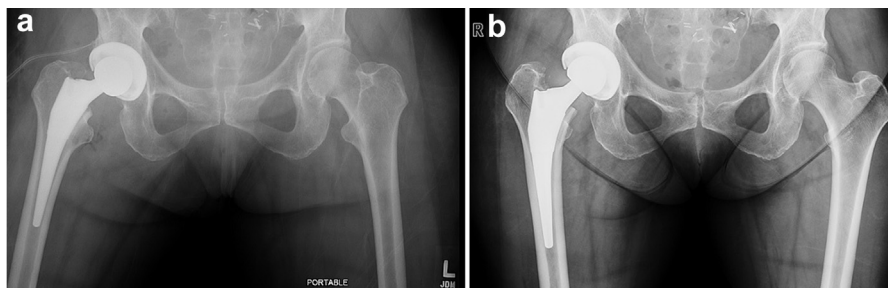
A representative anteroposterior (AP) radiograph from 1 of the 2 hips in which the femoral stem, presented in its original placement on a portable radiograph (a), subsided 4 mm as demonstrated on a radiograph taken at the first postoperative visit (b).
